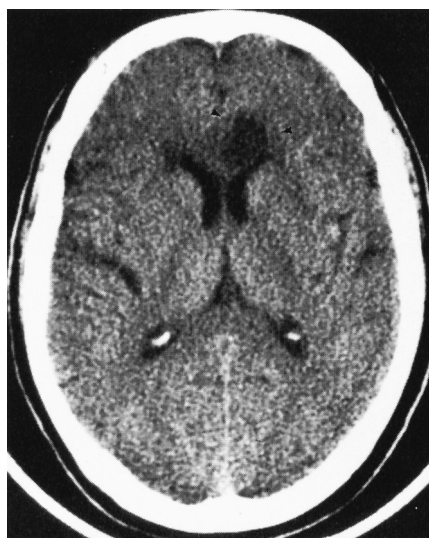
CT of ischemic stroke of the anterior cerebral artery (ACA). Note that the lesion is hypodense.
